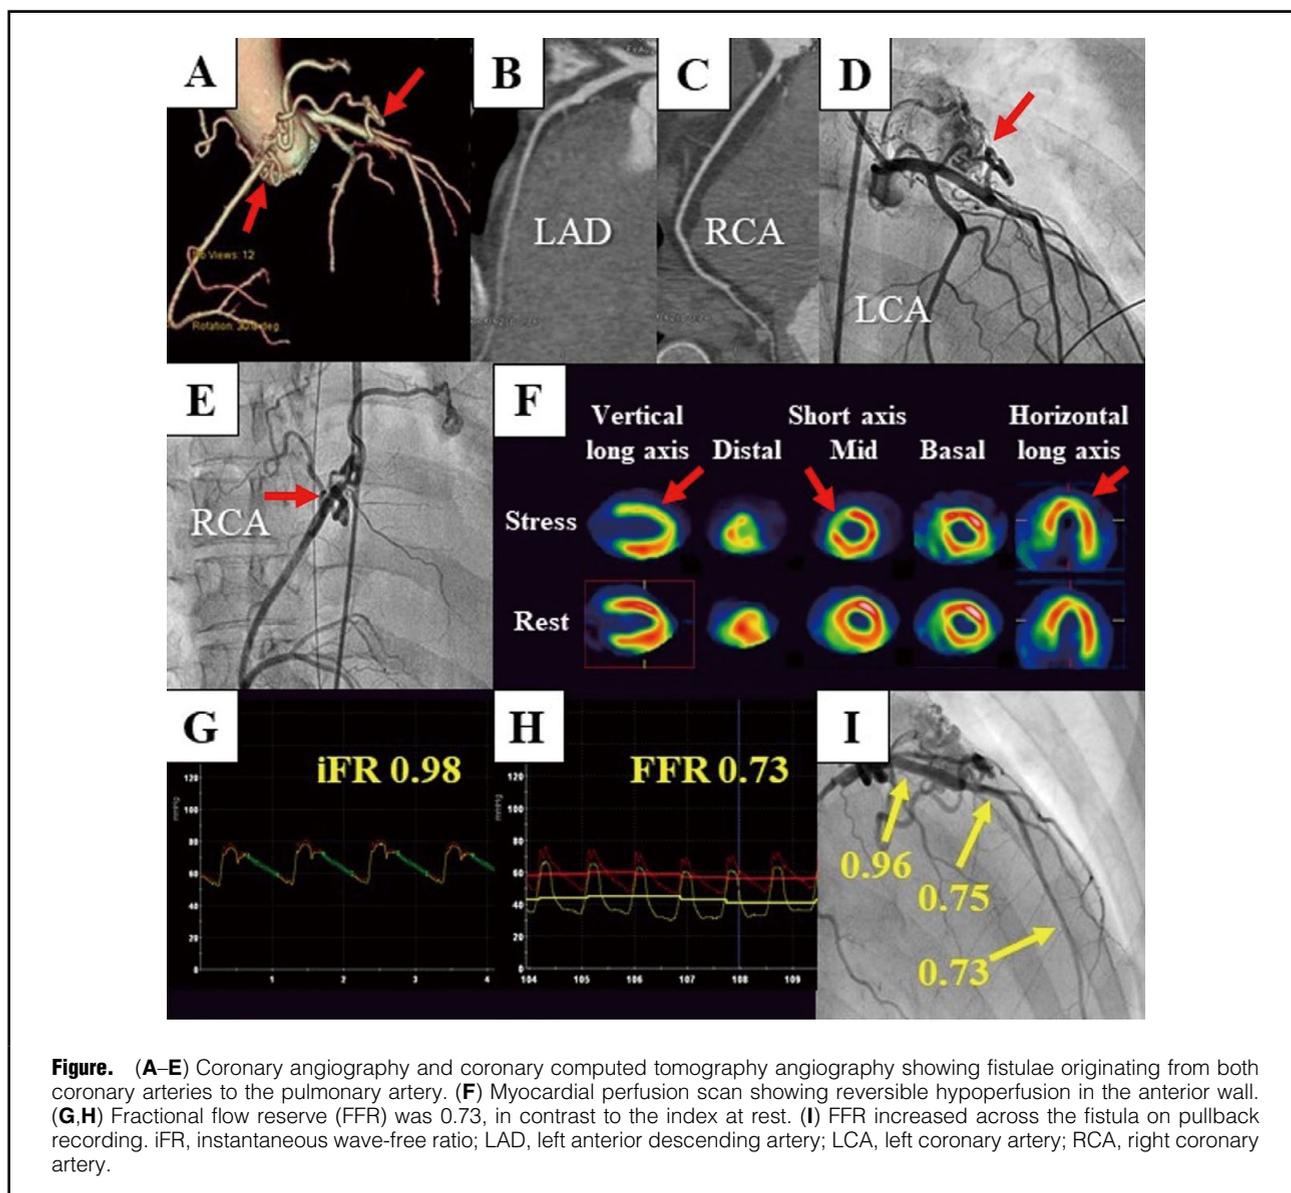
(A–E) Coronary angiography and coronary computed tomography angiography showing fistulae originating from both coronary arteries to the pulmonary artery. (F) Myocardial perfusion scan showing reversible hypoperfusion in the anterior wall. (G,H) Fractional flow reserve (FFR) was 0.73, in contrast to the index at rest. (I) FFR increased across the fistula on pullback recording. iFR, instantaneous wave-free ratio; LAD, left anterior descending artery; LCA, left coronary artery; RCA, right coronary artery.
